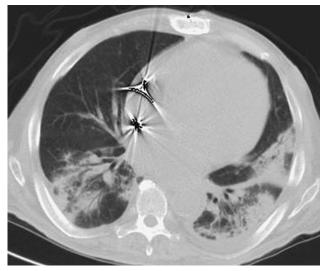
Computed tomogram showing bibasilar dependent opacities, left greater than right, as well as some ground-glass opacities
